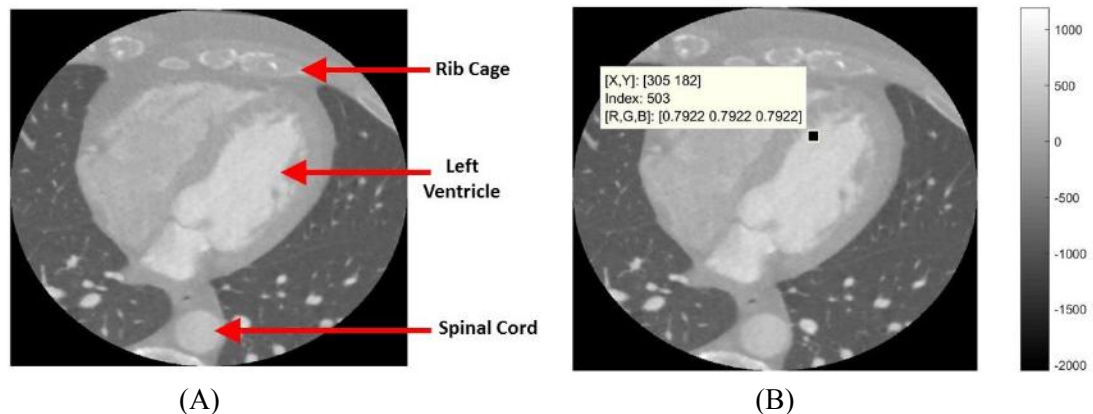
Typical mid-slice of a cardiac CT scan. (A) Mid-slice of a typical cardiac CT scan highlighting the different anatomical parts. (B) Data tip showing an approximate radiodensity value of the left ventricle.
